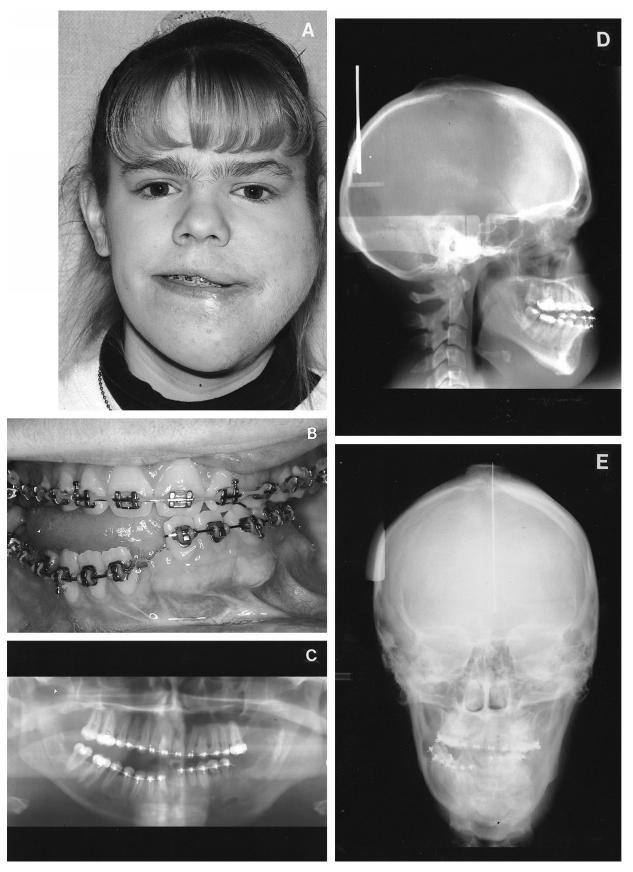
Patient at age 17 years. A. Patient prior to orthognathic surgery. Note hair overgrowth in the left preauricular and left chin area. B. Occlusion before orthognathic surgery. C. Progressive root resorption can be observed on the mandibular left incisors and premolars. Also note increased alveolar bone formation in the left molar and retromolar pad area. Lateral (D) and frontal (E) cephalometric radiographs at age 16 years. Continued open bite growth pattern and canted maxillary occlusal plane are evident.
